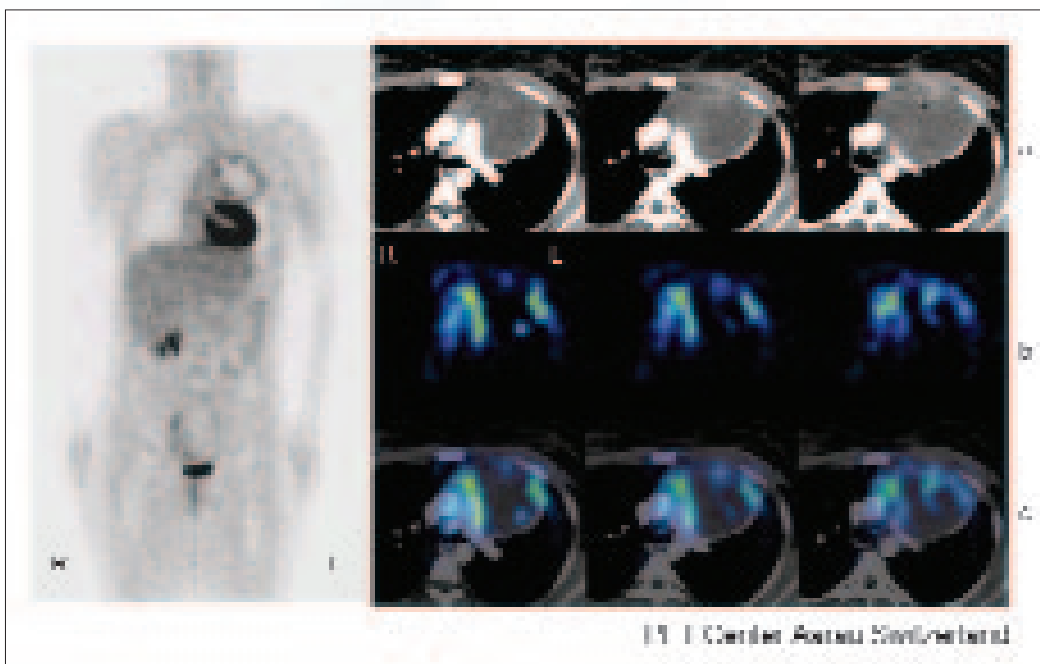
Imaging data from a 24-year-old female presenting with non-Hodgkins lymphoma. Results are from an intravenous contrast enhanced spiral and native CT of the thorax (a) and a dual-time whole body trunk PET (b; for diagnosis of viable residual mediastinal lymphoma mass). Image fusion (c) provides near precise localisation of the still viable, remaining lymphoma tissue following 3 cycles of chemotherapy. Image fusion of thoracic images from these dual modalities took approximately 30 minutes for data manipulation and actual fusion, and ultimately shows a good fusion result in a subset of thoracic images. However, such work flow is of very limited routine clinical utility. Currently, the same result cannot be accomplished for routine dual-modality whole body PET and CT, but is achievable with integrated PET/CT in a much shorter period of time.
